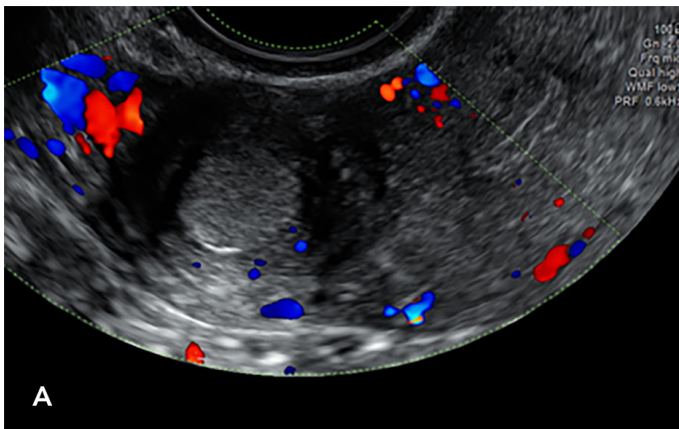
2D Ultrasound images of ACUMs in the left lateral myometrium showing the myometrial mantle and haemorrhagic content that can be hyperechogenic (A) or “ground glass” in appearance (B).
